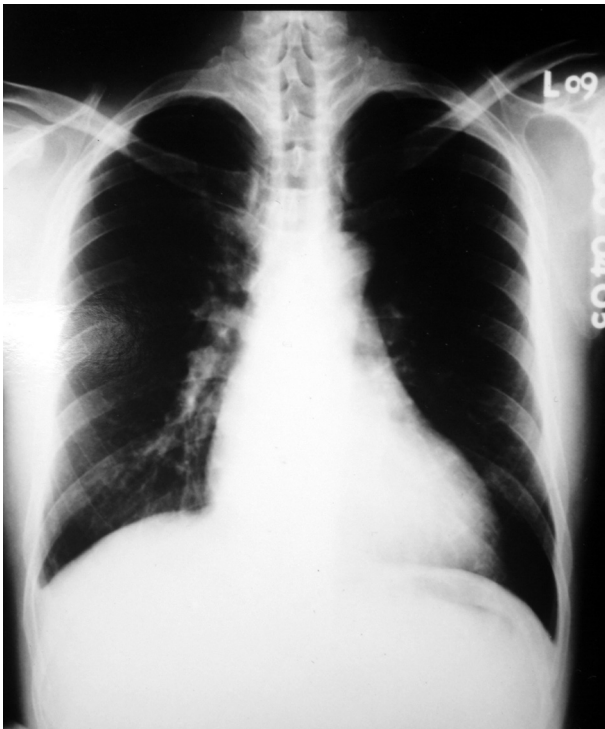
Chest roentgenogram reveals cardiomegaly with tortuous aorta. No active pulmonary lesion is found.
